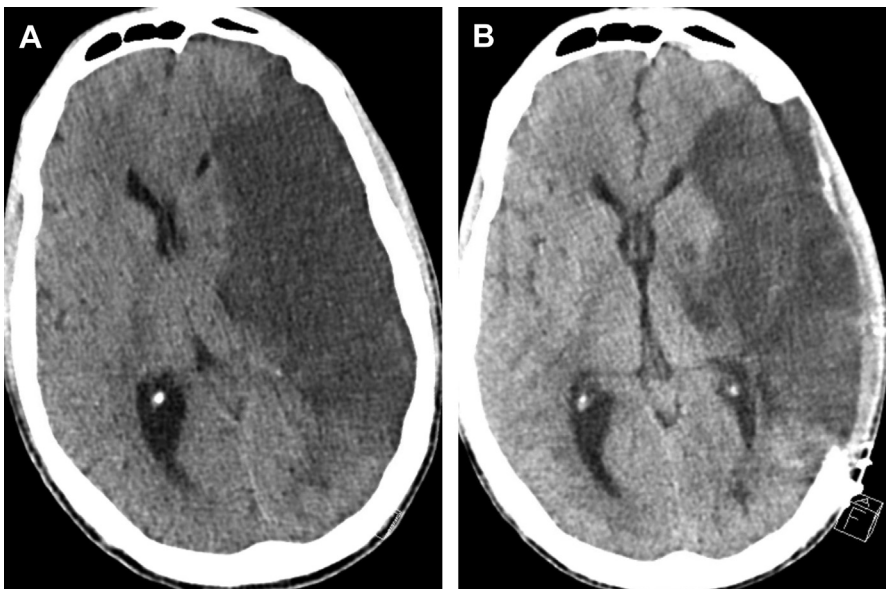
(A) Noncontrast head CT scan showing new left MCA ischemic stroke 48 hours post-onset of symptoms, with cerebral edema and midline shift. (B) Noncontrast head CT of same patient 24 hours post-DHC with near resolution of shift. (Courtesy of The University of New Mexico, Albuquerque, NM.)
